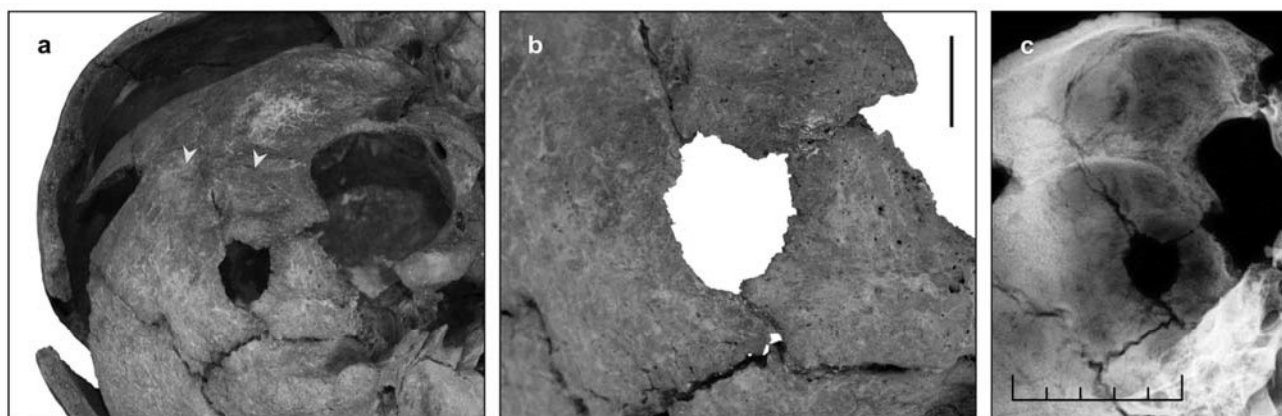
Several shallow depressions with pitting observed on the occipital bone of an elderly female, probably caused by chronic soft tissue inflammation (a), with a nearby oval-shaped opening (a, b). The edges of the defect are gently indented and rounded by the healing process (b). X-ray image (c) shows that the bone is thinned around the perimeter of the lesion without a sclerotic rim with evident clearing at the depressions. The indentation of the edges could thus have been caused by an effort to clean the wound. (Grave 4809; photo by Zdeněk Tvrdý and Jana Vachová; X-ray by Jan Holub).
